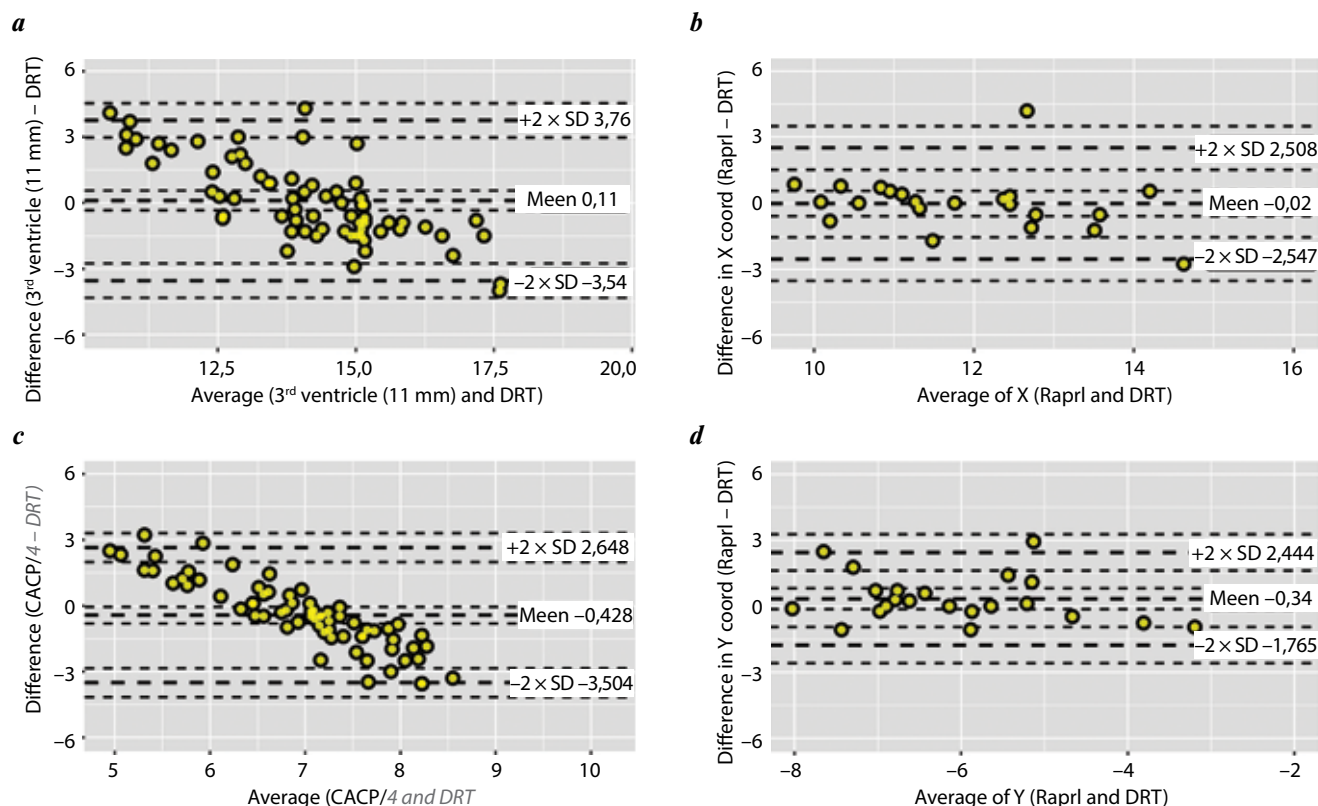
Blend–Altman plots: comparison of the position of the stereotactic coordinates of the dentato-rubro-thalamic tract (DRT) with the most commonly used target for indirect localization ventral intermediate nucleus (Vim) (11 mm lateral to 3rd ventricle, 1/4 of the distance between anterior and posterior commissure anterior to the posterior one) (a, b), and the target point calculated from the center of maximum hypointensity signal in the subthalamic region (Raprl) on FGATIR magnetic resonance images (c, d). The variability indices for the target point Raprl are significantly lower
